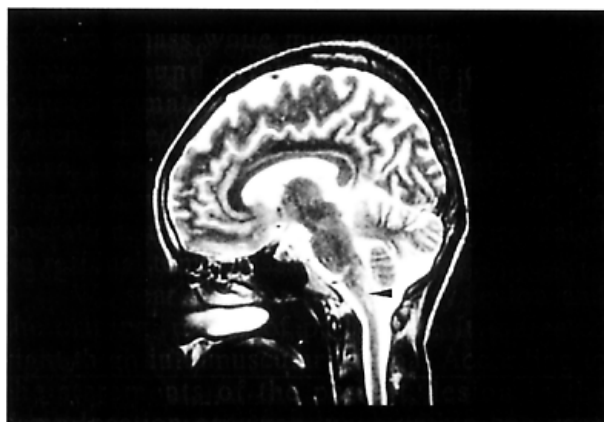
The brain MRI after the first attack (axial view): a vague high signal intensity lesion (arrow) on T2 weight image at the dorsal aspect of the medulla near the floor of the lower 4th ventricle.
